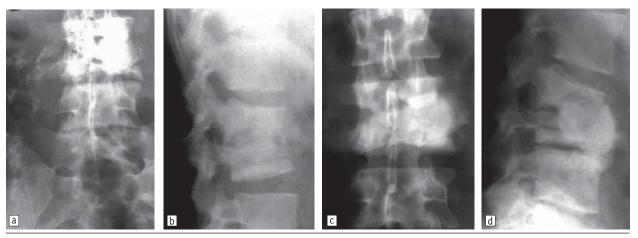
X-ray images of patient K., medical case history N 137
